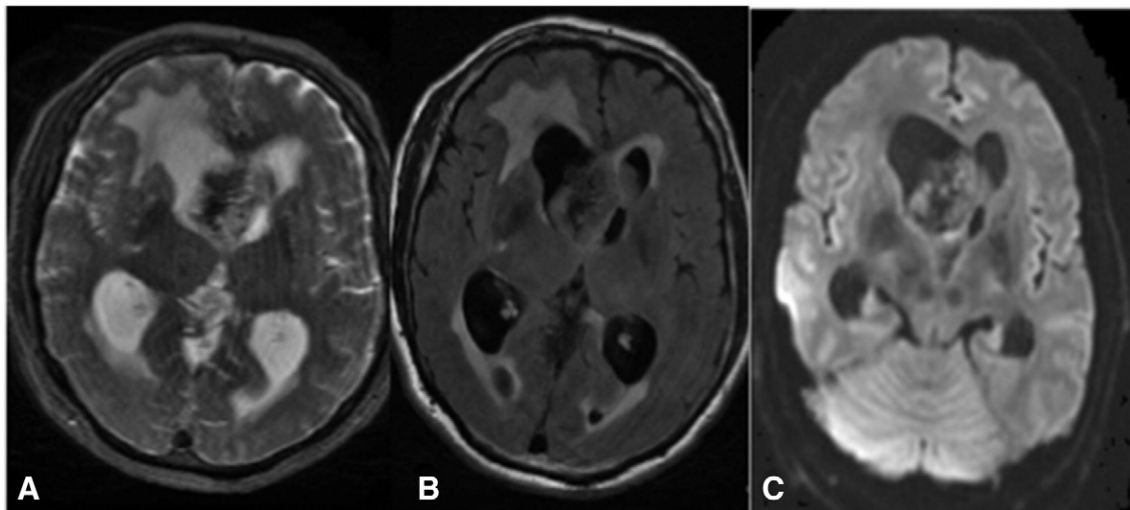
MRI preoperative examination. (A) Axial T1-weighted image demonstrates heterogeneously hypointense signal within the intraventricular mass. (B) Axial T2 FLAIR image shows hyperintensity in the periventricular white matter, consistent with transependymal edema and hydrocephalus. (C) Axial diffusion-weighted image reveals no significant diffusion restriction within the mass.
